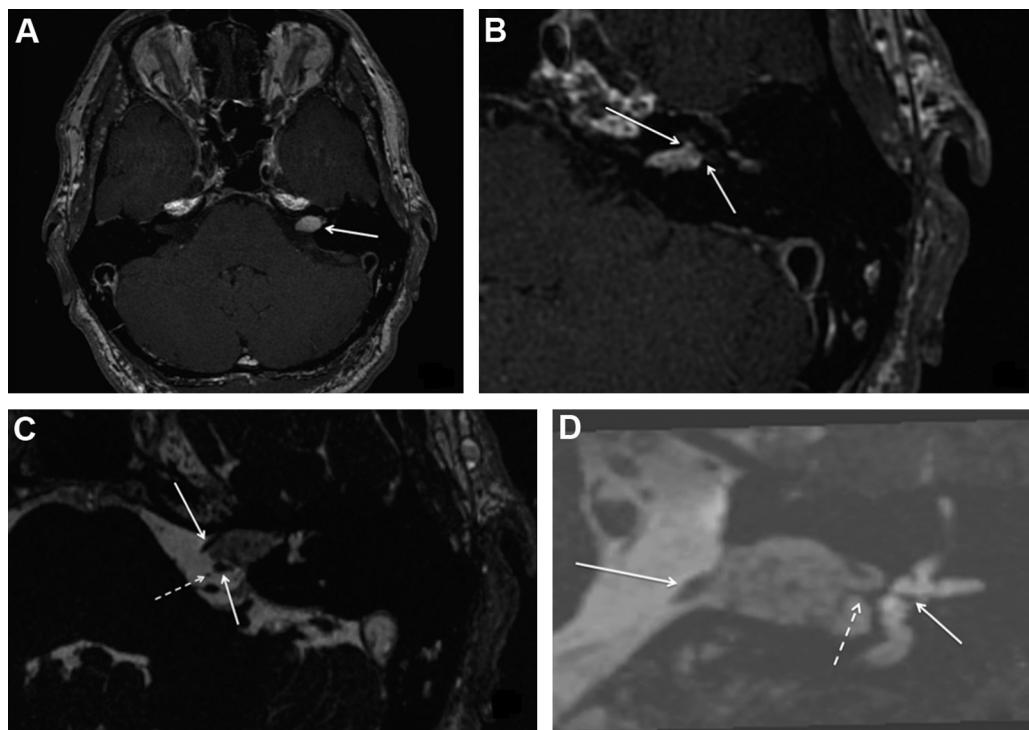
Cerebral weighted MRI (Unfortunately CT was not performed preoperatively); A: axial post contrast T1 showing an enlarged left IAC (diameter 5.6 mm vs 4.0 mm for the healthy side), a well-delineated 10-mm tumor (white arrow) with strong and homogeneous gadolinium enhancement, mimicking a stage 1 vestibular schwannoma; B: focus on the left IAC axial post contrast T1 shows the fundus filled with the enhancing lesion, which invades the cochlear recess of vestibule (left arrow) and adopts the inferior vestibular nerve direction towards the saccule of the inner ear (right arrow); C: left pontocerebellar angle in axial T2-FIESTA depicting a well-circumscribed hyperintense tumor into the IAC. In contact with the lesion at the porus sections of the cranial nerves may be observed, the VIIth anteriorly (superior arrow) to the lesion and the VIIIth (inferior arrow) posteriorly, with the antero-inferior cerebellar artery (AICA, dotted arrow) (Labyrinthine artery unperceivable); D: focus on the left IAC T2-FIESTA coronal reconstruction shows the moderate-hyperintense tumor enlarging the IAC. VIIth nerve (left arrow), transverse crista falciformis (dotted arrow) and the hyperintense inner ear labyrinth, with its hypointense utricular macula (right arrow), are shown.
